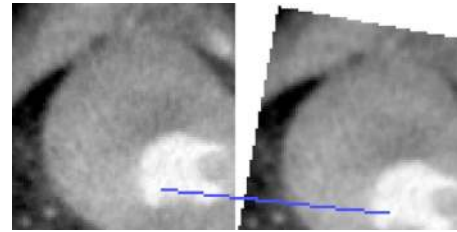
Line connects an example point pair corresponding to matched n -SIFT features in 4-D CT slices Table VI.
